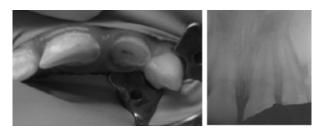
Initial clinical image (left) of patient 2 h after trauma with fractured left maxillary central and lateral incisors. Initial radiograph (right) showing loss of dental structure and enlargement of the periodontal ligament of the left maxillary central incisor and an absence of root or alveolar bone fractures.
